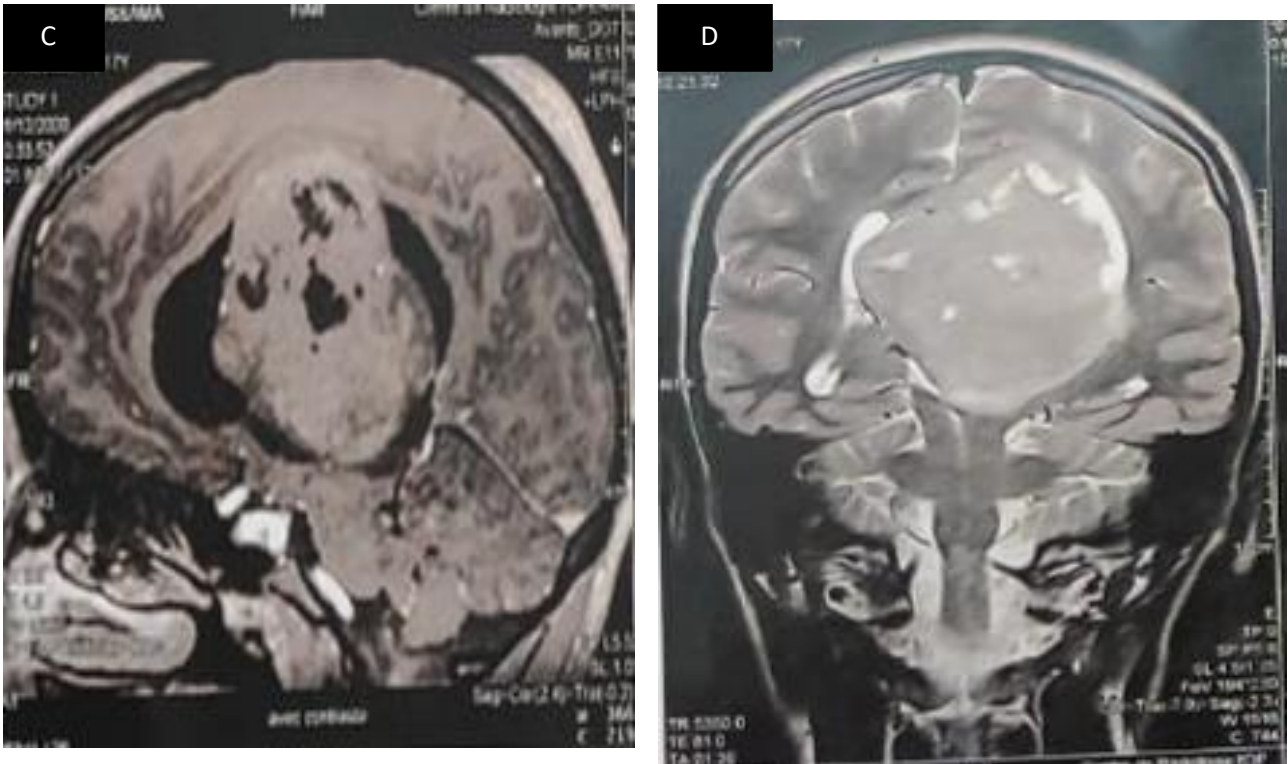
Magnetic Resonance Imaging (MRI) of the brain: Sagittal T1 post-contrast (C) and Coronal T2W (D) images showed a slightly hyperintense on T2-weighted sequences with mild heterogeneous enhancement after gadolinium injection.
